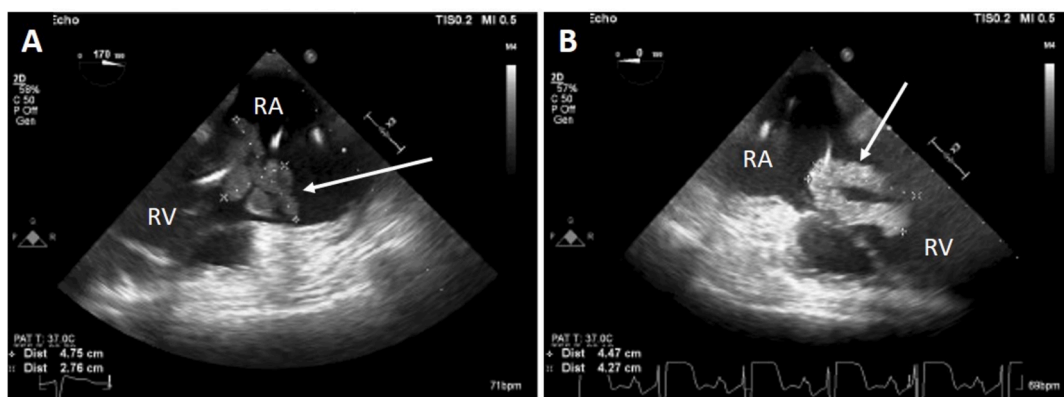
Intraprocedural Transesophageal Echocardiogram (TEE) of Right Heart Thrombus. Intraprocedural TEE, midesophageal views at (A) 170 degrees and (B) 0 degrees of the right atrium (RA) and right ventricle (RV) demonstrate a large multilobulated mass (arrow) encasing approximately 4.5 cm of a right atrial lead, with the highly mobile mass/lead complex prolapsing across the tricuspid valve in diastole.
